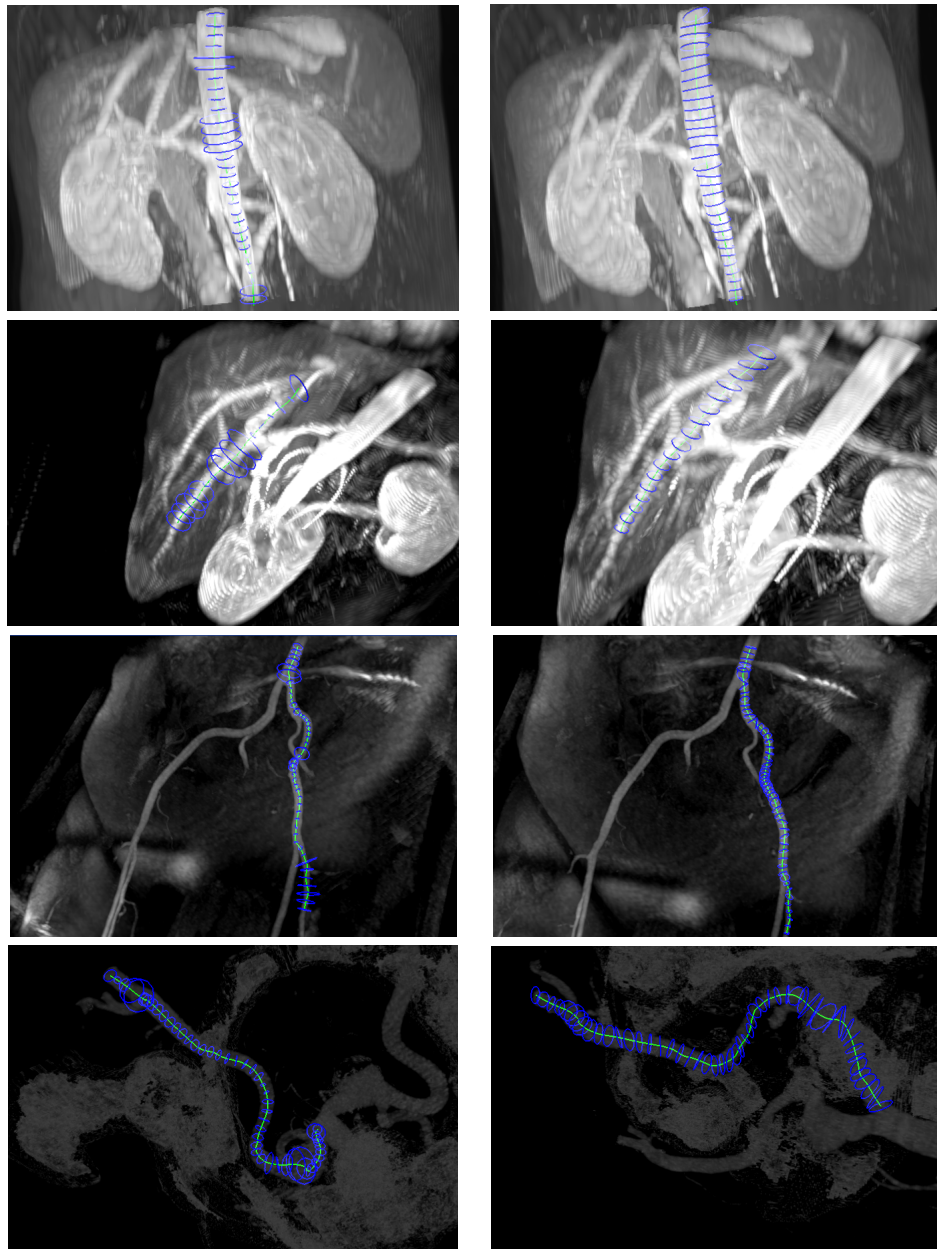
Volume rendering of real datasets with rendering of estimated vessel sections. Delineated centerlines are shown in green and estimated sections in blue. For each row, from top to bottom, results for an aorta in a MRI, one major liver vessel in the same MRI, and iliac arteries for a MRA (third row) and CTA (fourth row) study. Left column depicts the results of the first, direction estimation stage. Right column shows the results after the evolutionary optimization procedure.
